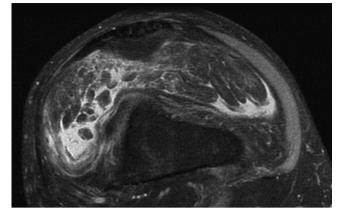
Axial fat-saturated T2-weighted magnetic resonance image shows complete saturation of the signal forming the villous structures, therefore confirming their fatty composition
